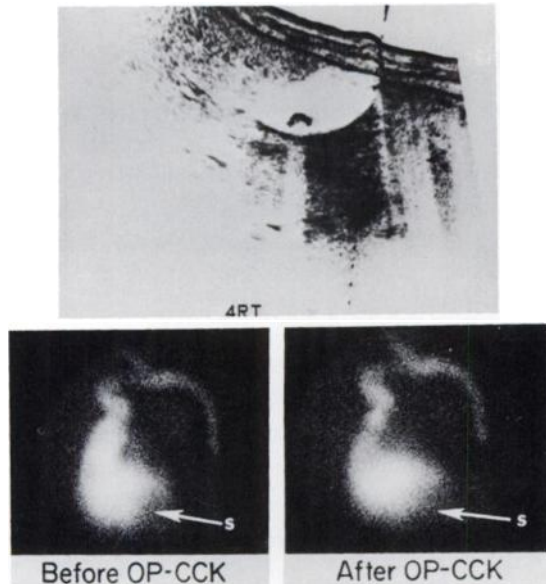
Biliary dynamics in cholelithiasis. Ultrasound study (top), shows large gallstone with prominent acoustic shadow. Biliary Tc-99m HIDA images (middle) show uniform caliber of common bile duct, twisted neck, and a filling defect (S) due to stone (left) at fundus of gallbladder, defect becoming less clear after OP-CCK (right). Bile reflux into common hepatic duct is seen throughout gallbladder ejection period, and curve for common bile duct shows no peak. Gallbladder ejection fraction is 28% and ejection rate 3.1%/min. Note rapid gallbladder refilling to $\frac{3}{4}$ of its original volume, probably with bile that had refluxed into common hepatic duct (bottom).
